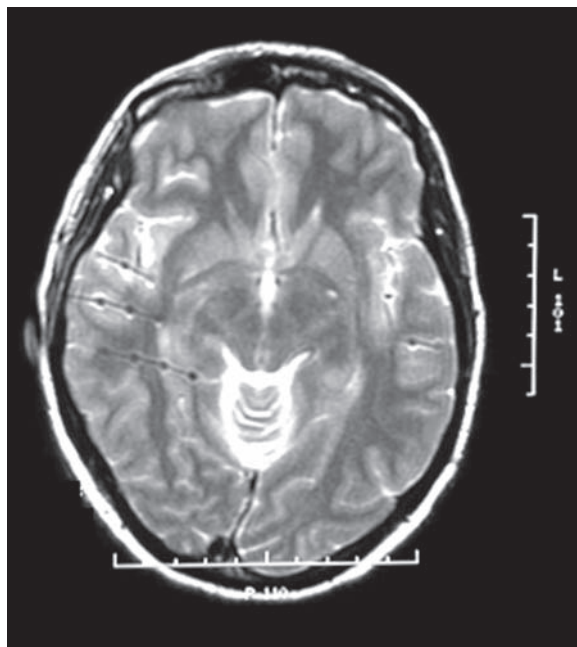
Depth electrodes. A 25-year-old man had complex partial seizures preceded by a stereotyped olfactory aura. MRI was normal, and ictal scalp EEG recordings had suggested that the seizures had a right temporal onset. This was confirmed with depth electrode recordings, with three electrodes placed in the right temporal lobe and one in the left temporal lobe
